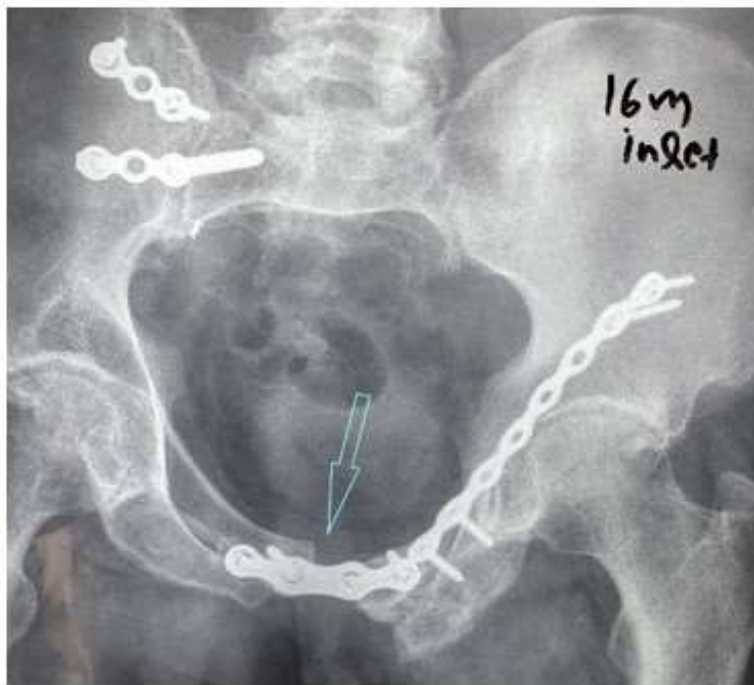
Case 2. Left side: The x-ray 16m postoperatively depicts the residual malposition of the pubic symphysis due to the difficulty we had to manipulate and reduct it.
